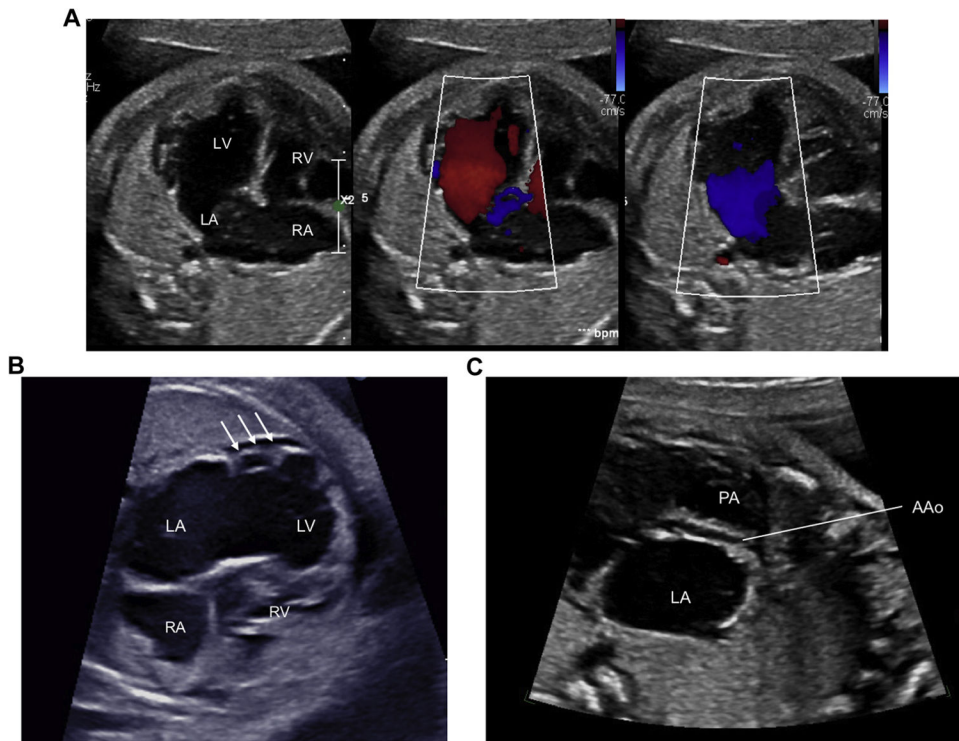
Fetal Echocardiographic Findings
